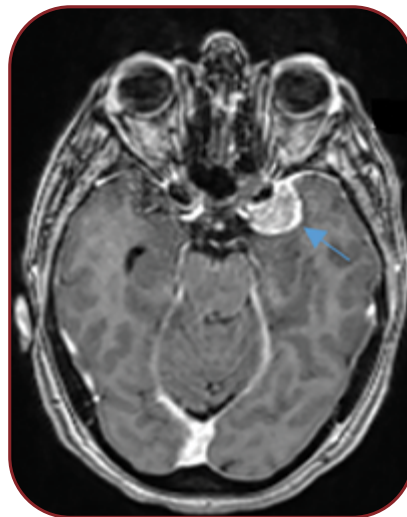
T1-weighted gadolinium-enhanced sequence showing a homogenously strongly enhancing meningioma at the temporal lobe
